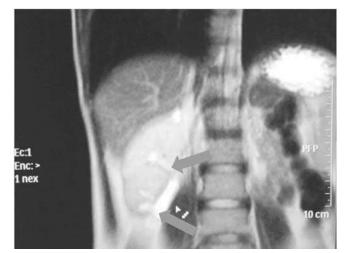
MRI: Double collecting system
